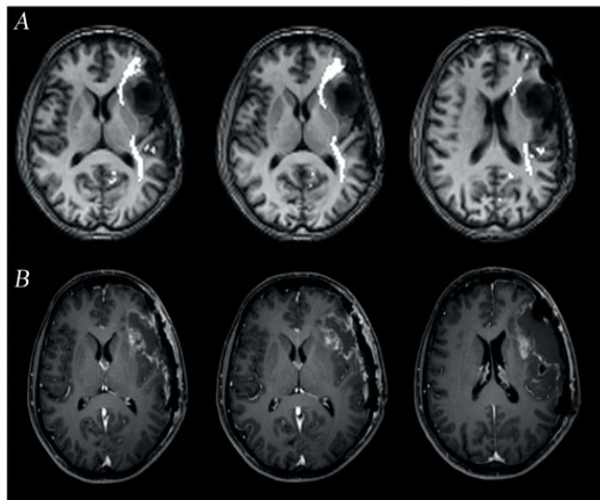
(A, B). IFOF reconstruction in a case of left frontal recurrent low-grade oligodendroglioma. The IFOF (white bundle) was reconstructed by DTI-FT and superimposed on morphologic T1-weighted images; the tract was dislocated and infiltrated by the tumor mass (A); the tract was identified intraoperatively by DES (onset of semantic paraphasia) in the same position where it was located by DTI-FT, as demonstrated by the postoperative postcontrast T1-weighted images (B)
